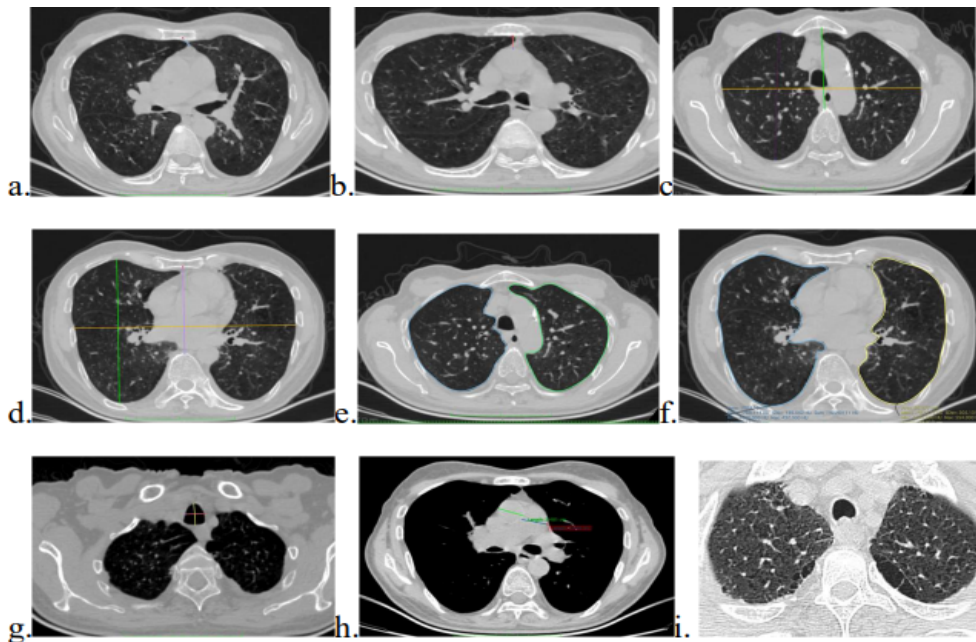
56Y male smoker with breathlessness; Spirometry shows mild airflow obstruction (FEV1/FVC < 0.7, FEV1 85%, FVC 121%) consistent with GOLD Stage 1 COPD and HRCT parameters as below.
